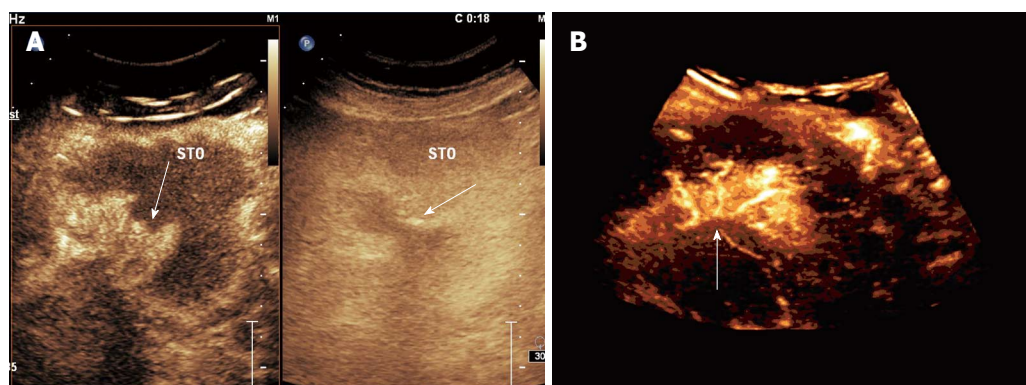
Double contrast-enhanced ultrasound imaging of ulcerative gastric cancer. A: Two-dimensional double contrast-enhanced ultrasound (DCUS) images (conventional imaging on the right and harmonic imaging on the left) showed a contrast-enhanced mass with crater-like ulcerative defect (arrow); B: Three-dimensional DCUS imaging showed distorted nourishing vasculature within the gastric cancer (arrow).
